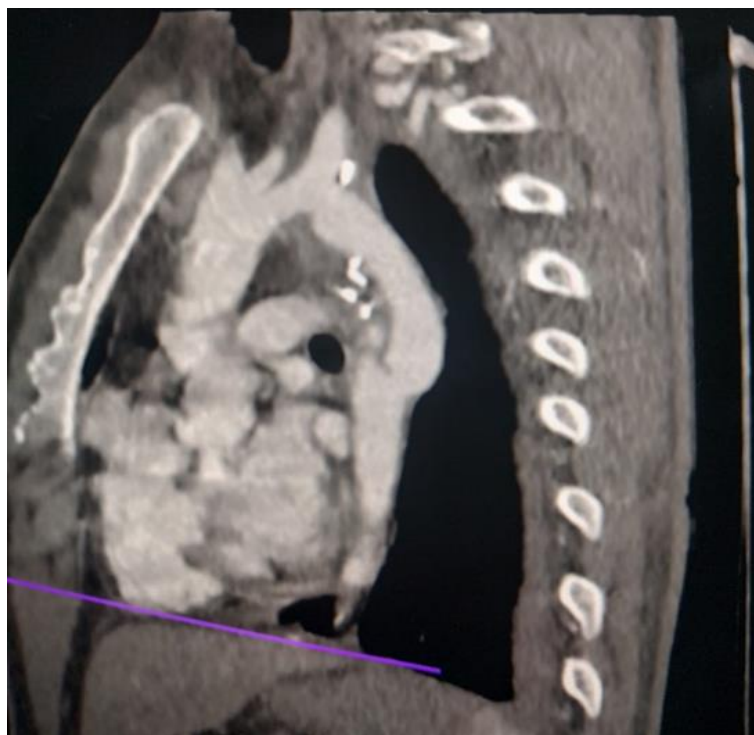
CT Scan Showing Aortic Coarctation Pre-Treatment
